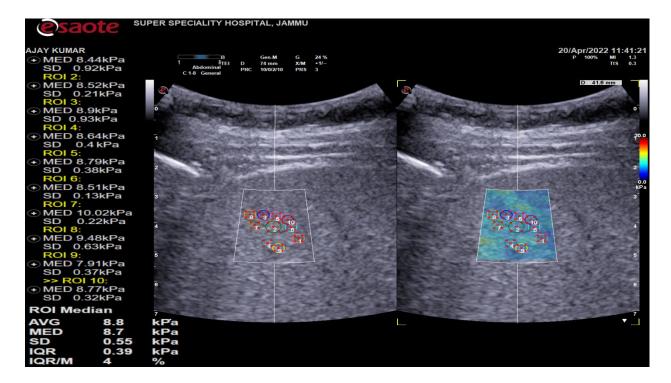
ultrasound examination of a liver with moderate steatosis, as characterized by increased echogenicity of the liver parenchyma and posterior attenuation of the ultrasound beam. The attenuation of the ultrasound beam decreases the definition of the hepatic vessels increased echogenicity of the liver parenchyma. 2D-SWE study showing stiffness of 8.8kPa, consistent with a METAVIR stage of F2. The elastography map is homogeneous and predominantly blue, indicating less stiffness.
